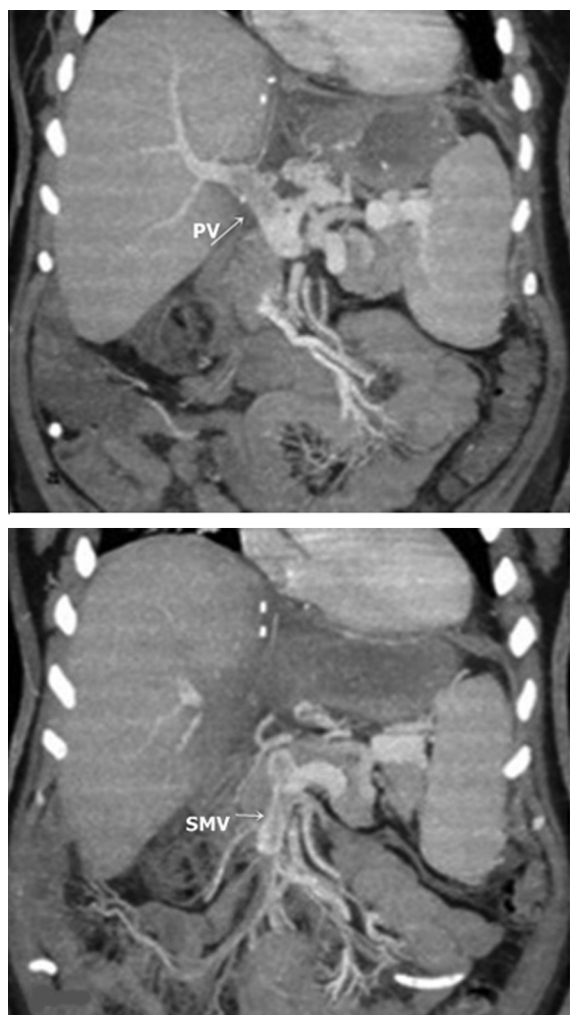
Fifty-one year old male recipient 2 weeks post LDLT, with suspected PVT on Doppler US. (a & b) coronal CT angiography MIP images showed partial portal and superior mesenteric vein thrombosis.
